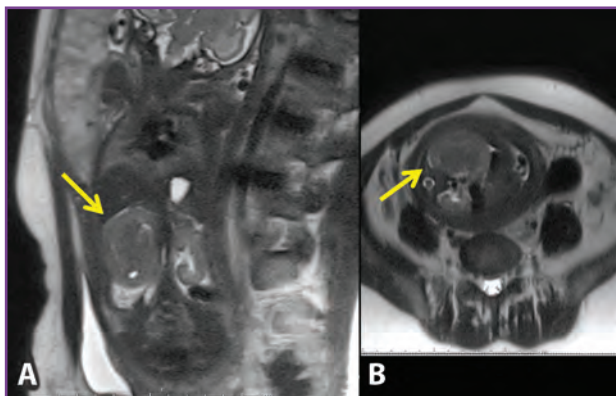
Sagittal (A) and axial (B) prenatal T2-weighted magnetic resonance images show a right renal mass (arrows).
